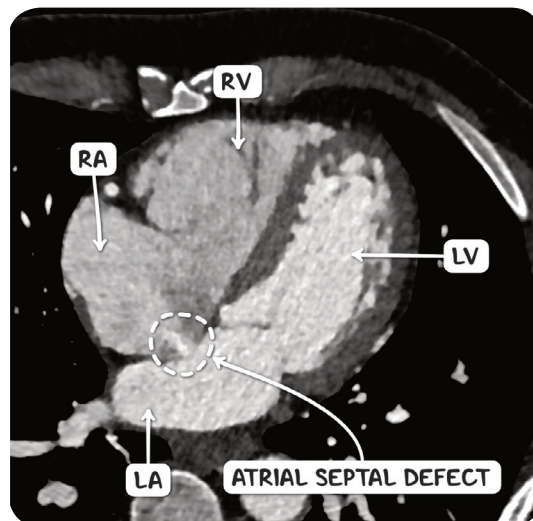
CT scan in the axial plane showing an atrial septal defect. Note the faint contrast plume as blood flows from the high pressure left system to the low pressure right system. RA; right atrium. LA; left atrium. RV; right ventricle. LV; left ventricle.
